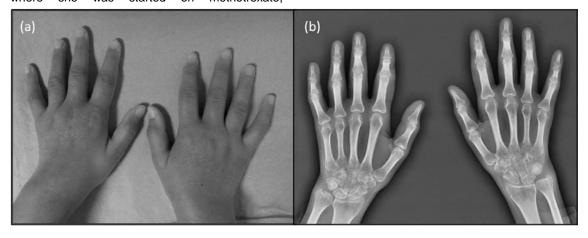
(a) Clinical presentation of the patient (b) Radiography of the patient.
